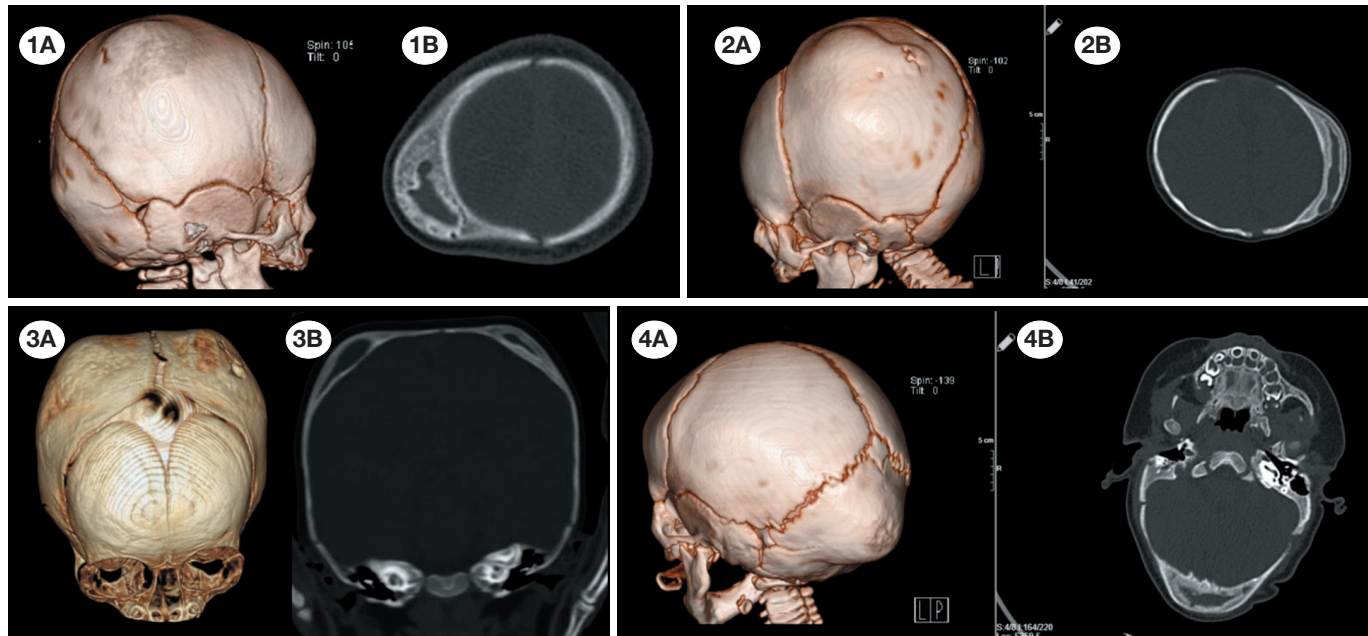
3D and axial computed tomography images of the cases. 1A-B Right, 2A-B left, 3A-B bilateral and 4A-B occipital ossified cephalic hematoma.
